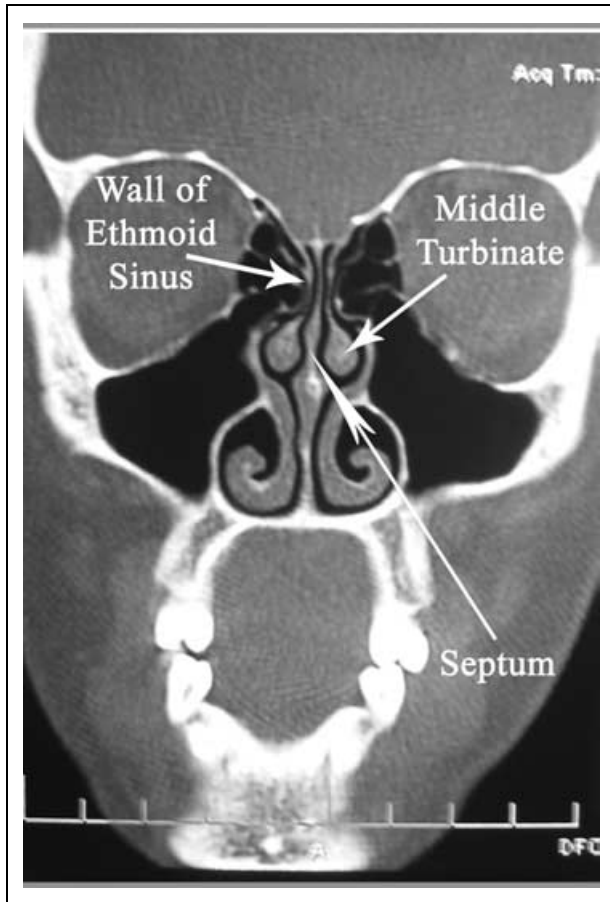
This is a CT of a patient who does not demonstrate any contact between the septum and the lateral nasal wall. Please note the arrows showing the medial wall of the ethmoid sinuses, the middle turbinate, and the septum.
